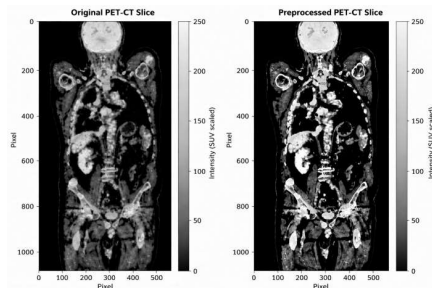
Original and Preprocessed Whole-Body PET-CT Images
